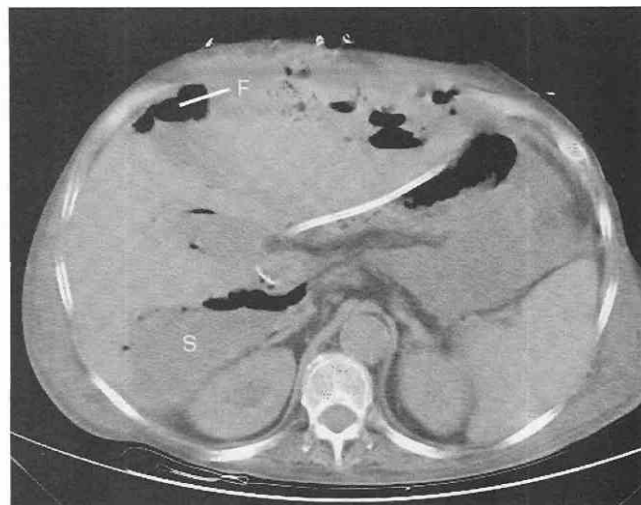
CT scan shows free air (F) in the anterior subhepatic space adjacent to the gallbladder fossa. The posterior right subhepatic space (S) lies so high that it gives the erroneous impression of a hepatic fluid collection.
